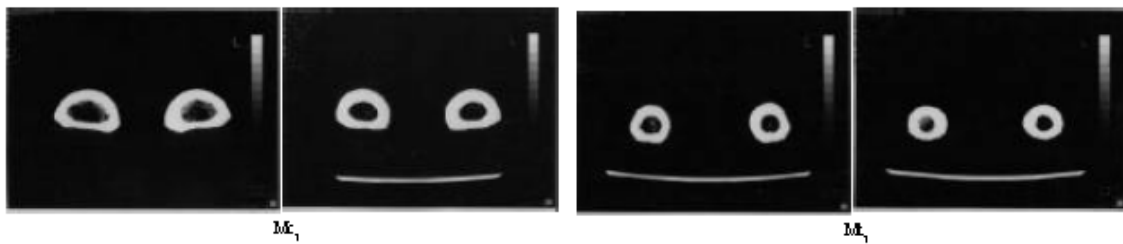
Computed tomography images of  $Mc_3$  and  $Mt_3$
